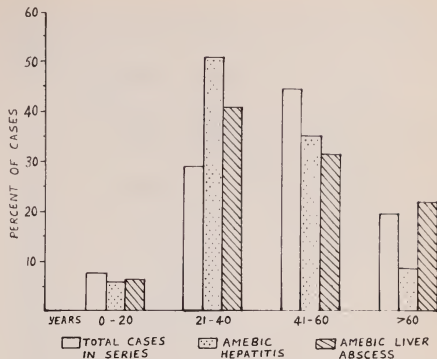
Age distribution in hepatic amebiasis: no significant difference from total series with scintigraphic studies.
